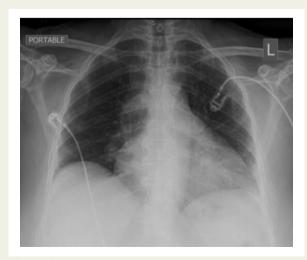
Figure I Initial presentation chest X-ray with normal lung fields.
